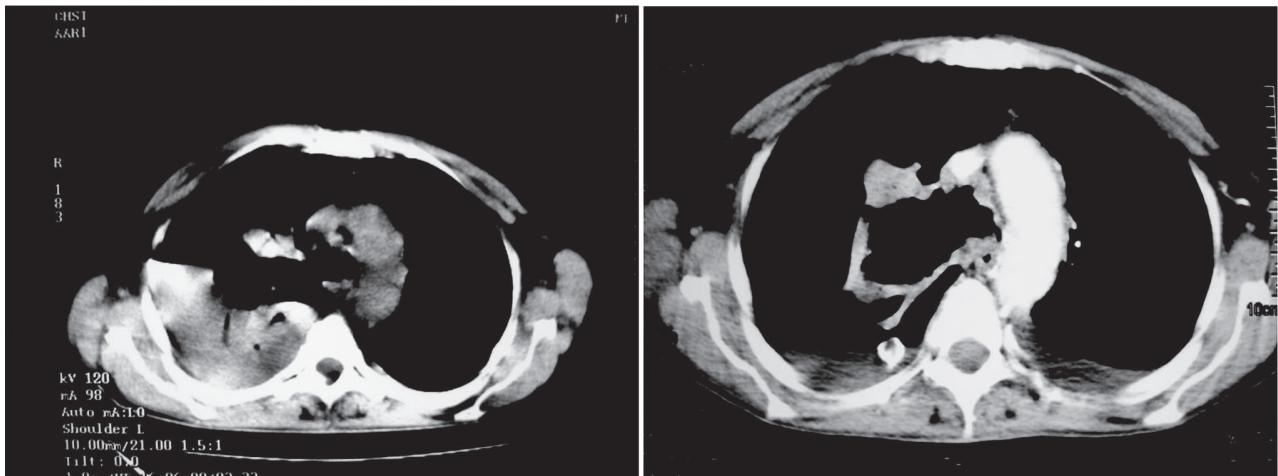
Left: Computed tomogram shows a cavitary lesion on the right tracheobronchial angle. Right: The hydropneumothorax has been drained with a chest tube.
